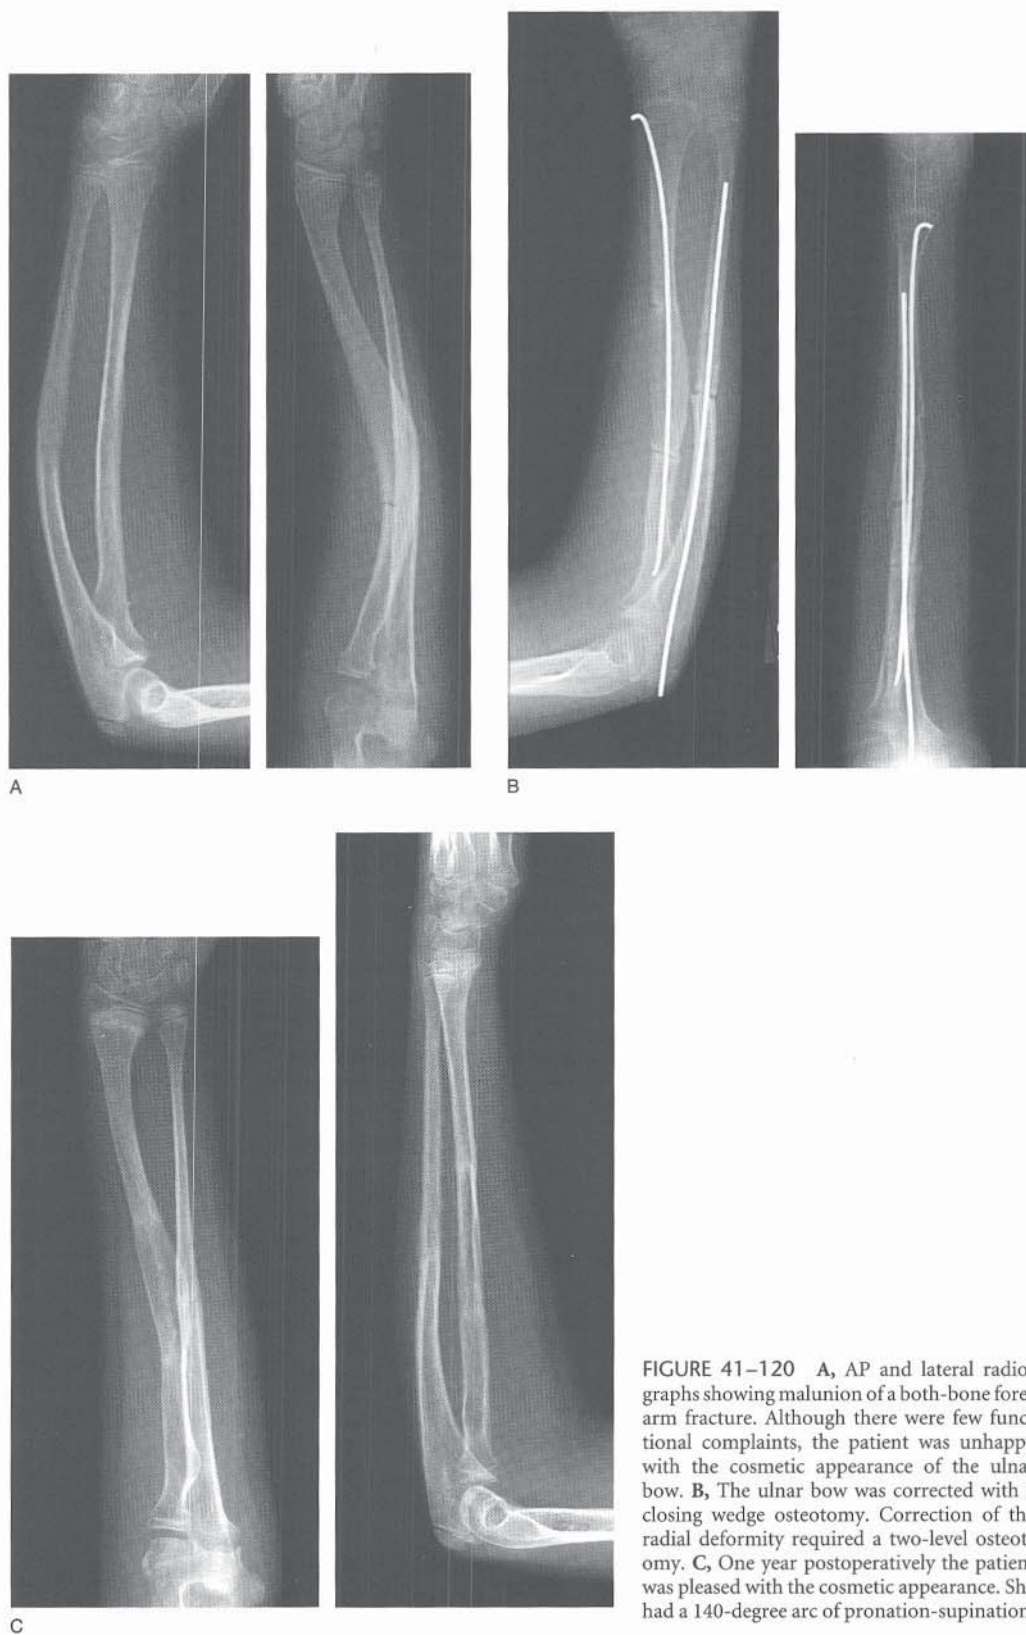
A, AP and lateral radiographs showing malunion of a both-bone forearm fracture. Although there were few functional complaints, the patient was unhappy with the cosmetic appearance of the ulnar bow. B, The ulnar bow was corrected with a closing wedge osteotomy. Correction of the radial deformity required a two-level osteotomy. C, One year postoperatively the patient was pleased with the cosmetic appearance. She had a 140-degree arc of pronation-supination.
